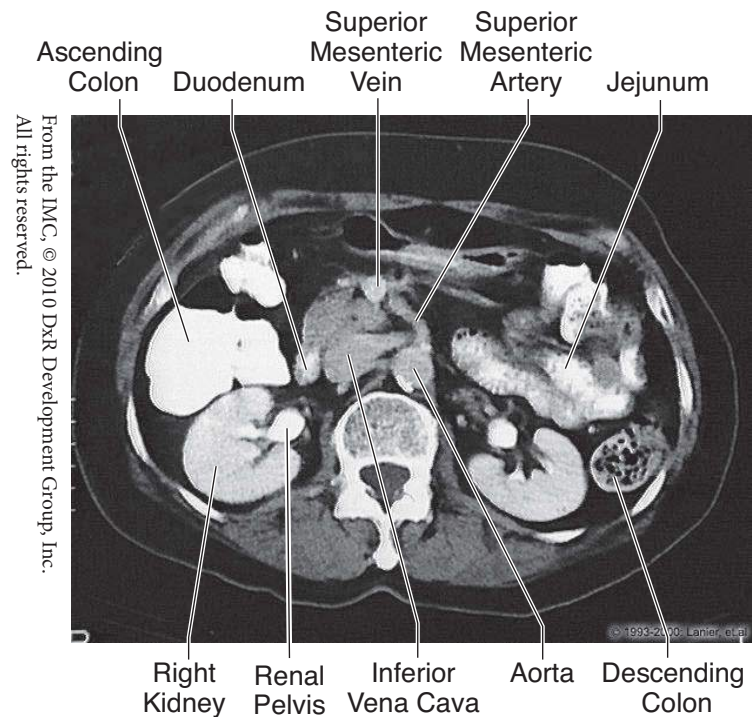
Abdomen: CT, L2
